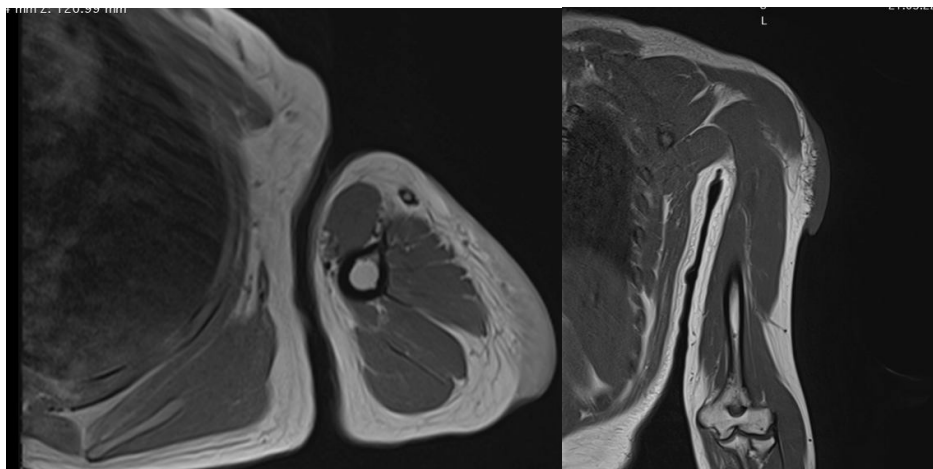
MRI of the left arm, axial and coronal section in T1-weighted sequence without injection of gadolinium: lesion process of the superior-external aspect of the left arm well limited, with regular contours in T1 hypo signal.
